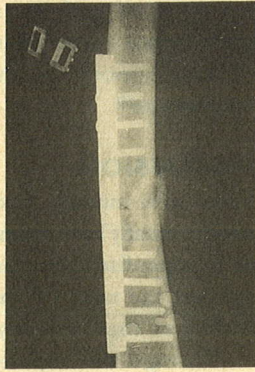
Immediate post-operative radiograph of the same case. The allograft bone paste is seen placed at the fracture site.
